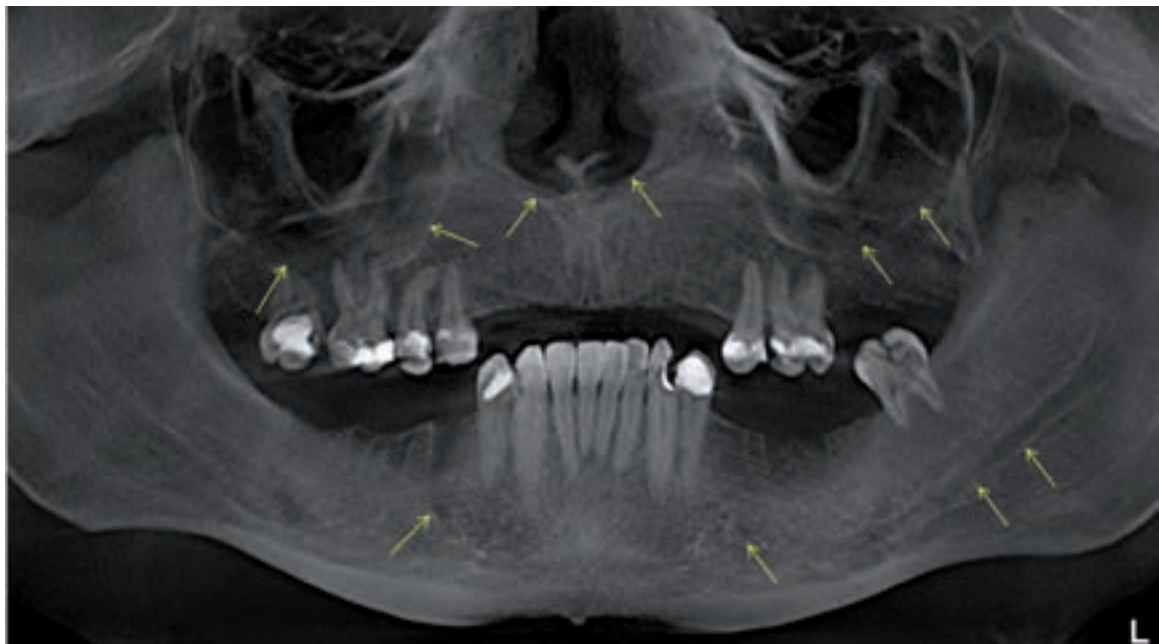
Panoramic radiograph showing anatomic structures.
